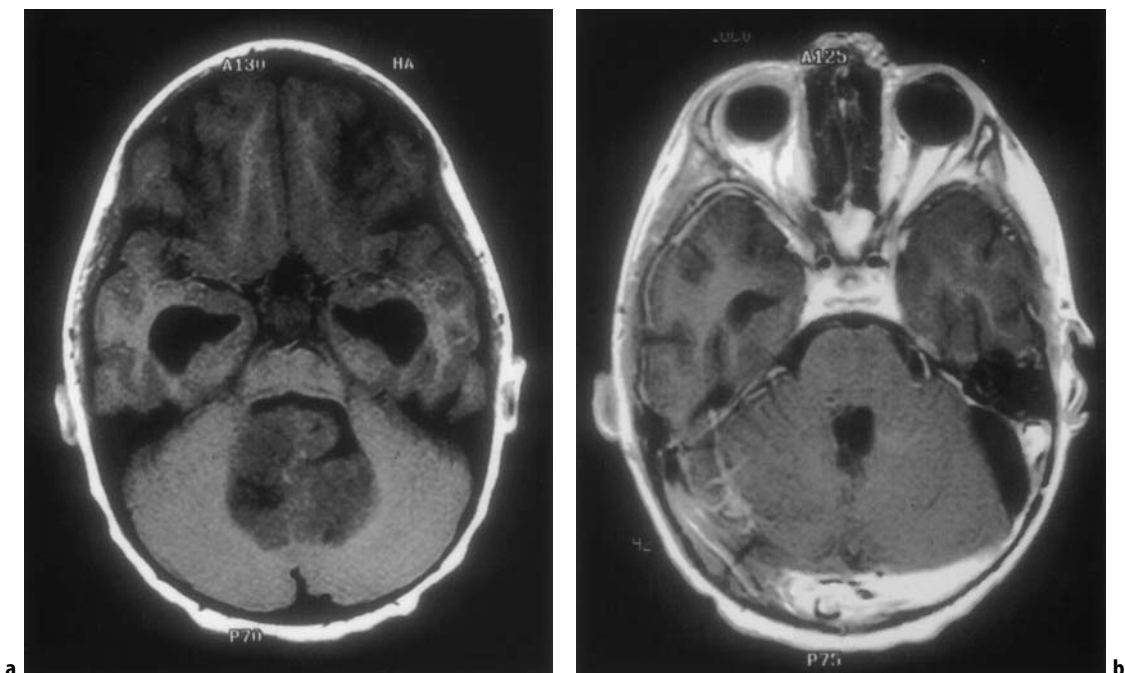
a Axial MRI (T1), showing moderately sized medulloblastoma. Typical of medulloblastomas, this tumor involves the roof of the fourth ventricle, without invading the floor. Also note the markedly enlarged temporal horns of the lateral ventricles. b Post-operative axial gadolinium-enhanced MRI (T1), showing resection of the fourth ventricular tumor, as well as resolution of hydrocephalus.
